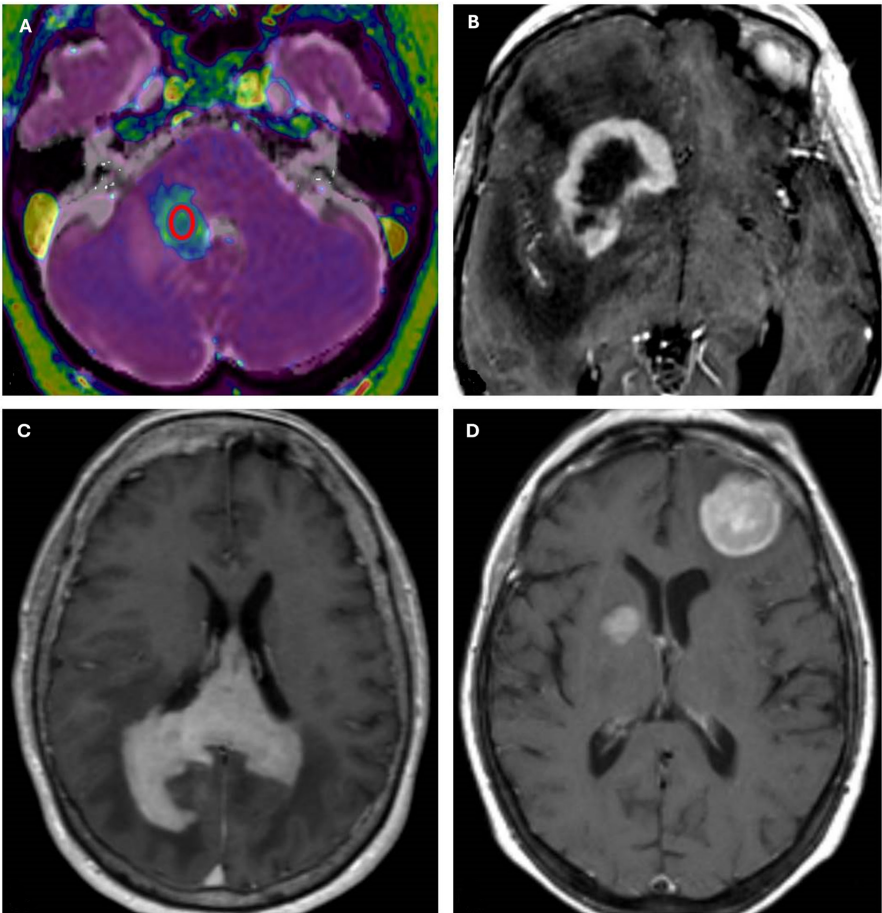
MRI features of primitive diffuse large B-cell lymphoma. (A) T1 magnetization prepared rapid gradient echo post-gadolinium administration/ADC co-registration. A region-of-interest (red circle) was drawn in the ADC map at the center of a right cerebellar lesion. (B) Ring enhancement indicative of central necrosis (post-contrast T1-weighted MRI). (C) Corpus callosum infiltration (post-contrast T1-weighted MRI). (D) Multifocal disease (post-contrast T1-weighted MRI). ADC, apparent diffusion coefficient.
